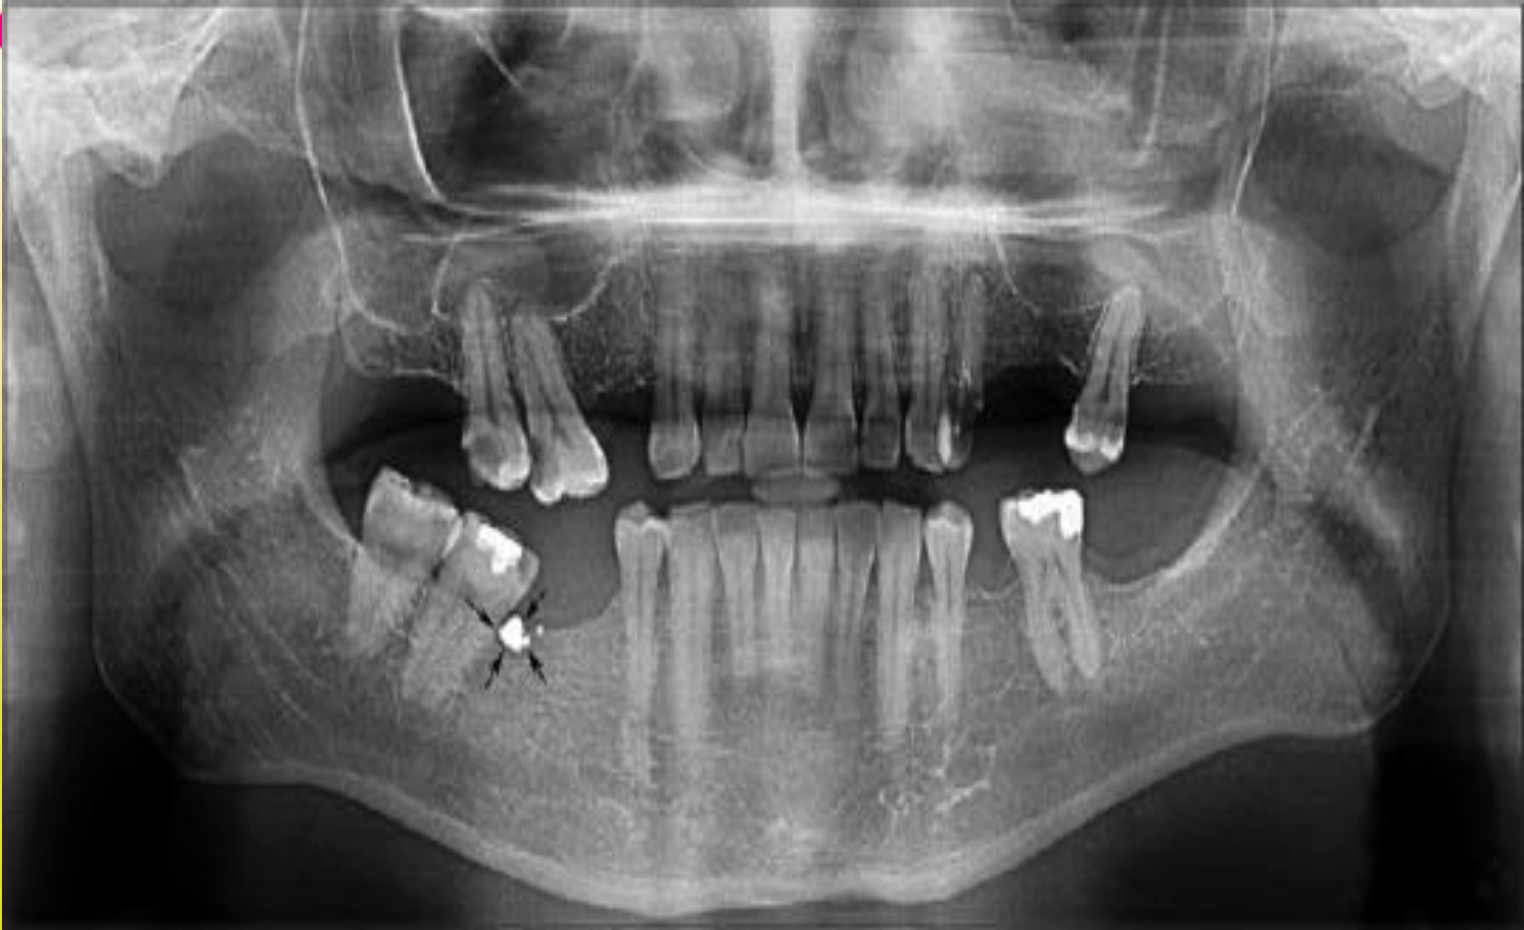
The mixed radiolucent and radiopaque appearance of a more mature stage of periapical cemento-osseous dysplasia. Note the radiolucent rim encircling the radiopaque foci of dysplastic bone.
